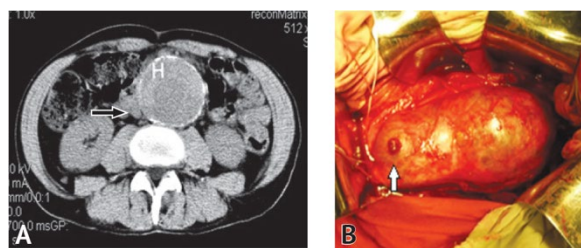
Computed tomography scan of the abdomen, axial section without contrast enhancement of a 66-year-old man admitted to the clinic with acute abdominal pain (A). In the lumen of the aneurysm, a crescent-shaped area of increased density (H) is clearly defined near the wall. The arrow also indicates an area of diffuse, heterogeneous compaction of the para-aortic tissue (extraluminal predictor of aneurysm rupture). B – intraoperative data: the tear in the anterior wall of the aneurysm is determined, indicated by the arrow (own data)
